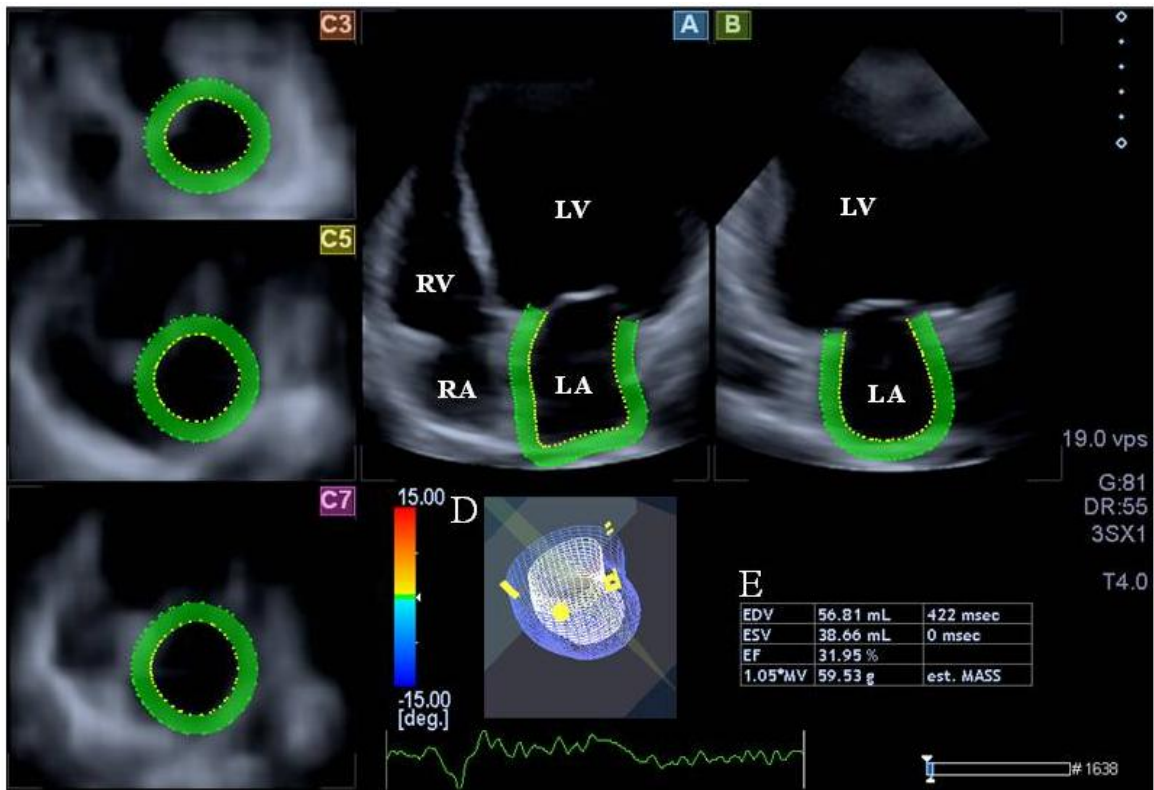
Three-dimensional echocardiographic dataset is displayed in apical 4-chamber (A) and 2-chamber views (B) and 3 short-axis views in the basal (C3), midatrial (C5), and apical (C7) regions, respectively. Three-dimensional cast (D) and calculated characteristics of left atrium are also presented (E).
